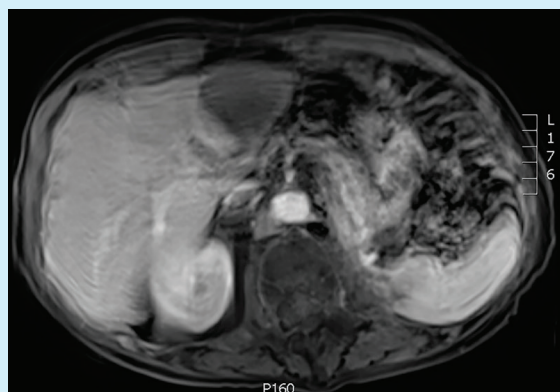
MRI performed 6 weeks later demonstrates a wide zone of ablation, with no residual disease or new lesions.
